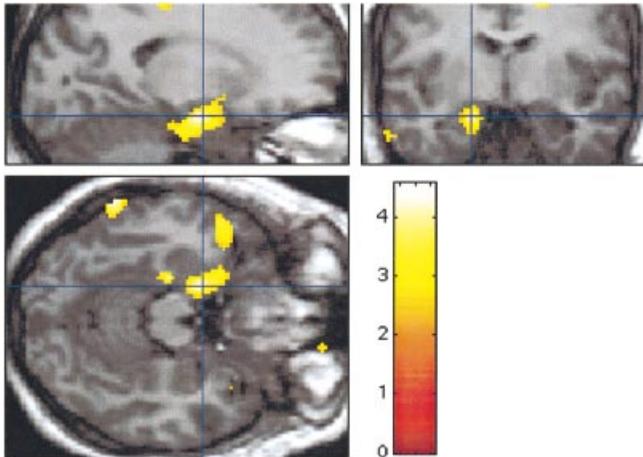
Example of a patient (Patient 8) with decreased FMZ- V_d in the ipsilateral hippocampus extending into the amygdala. Colour scale: Z score (maximum $Z = 3.71$). Statistical results are overlaid onto the patient's co-registered MRI. Only the mesial temporal decrease, highlighted with a cross-hair, is significant. The left side of the coronal image and the upper part of the transverse image correspond to the left side of the brain.
